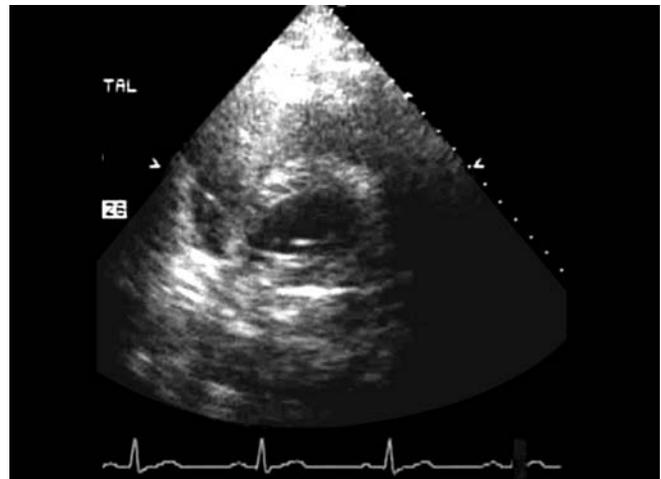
Parasternal short-axis view.
